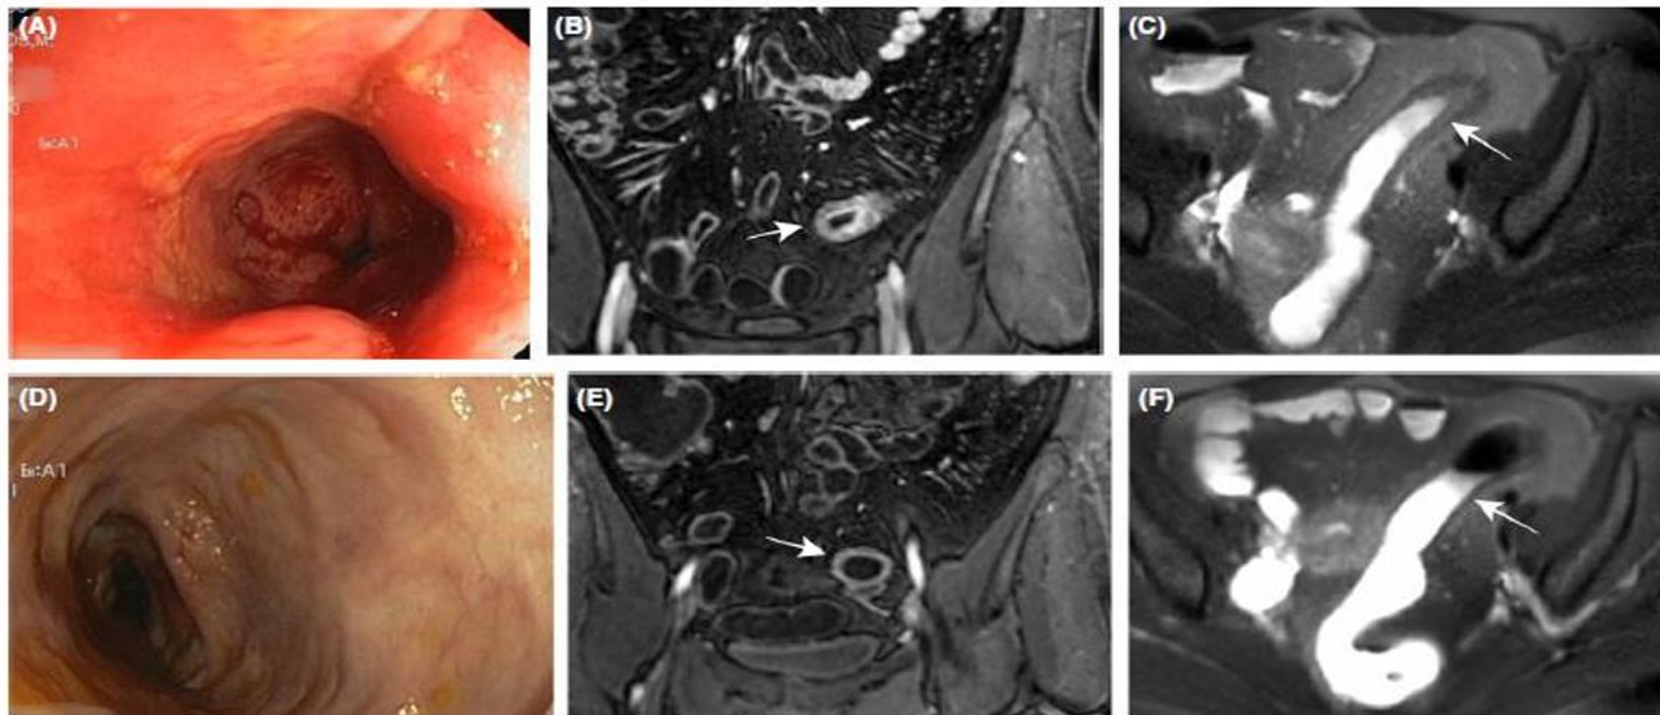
Ileocolonoscopy of a 31-year-old female with CD showed severe inflammation and ulcers of the sigmoid colon (A). MRE of the same patient showed a moderate thickening and hyperenhancement of the sigmoid wall in T1-gadolinium enhanced sequences (arrow in B) together with mural oedema on T2-weighted sequence with fat saturation at the same segment (arrow in C). After 52 wk of HSCT, the same patient reached endoscopic remission (D). MRE confirms disease transmural improvement by showing reduction of wall thickening on T1-gadolinium enhanced sequence (arrow in E) and absence of oedema on T2-weighted sequence (arrow in F) but persistence of some bowel wall thickening (arrow in E)
